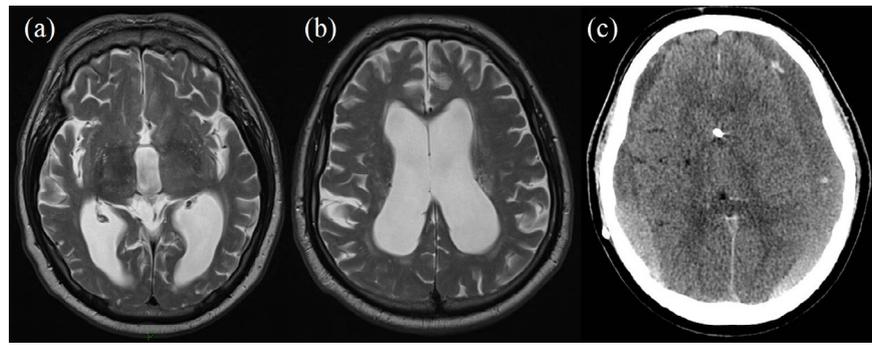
MRI Scan (a, b) Shows Dilated Ventricular System in a Patient Clinically Presenting with Normal Pressure Hydrocephalus. Post Drainage, CT (c) Shows Bilateral Subdural Haematomas with a Decompressed Ventricular System.
